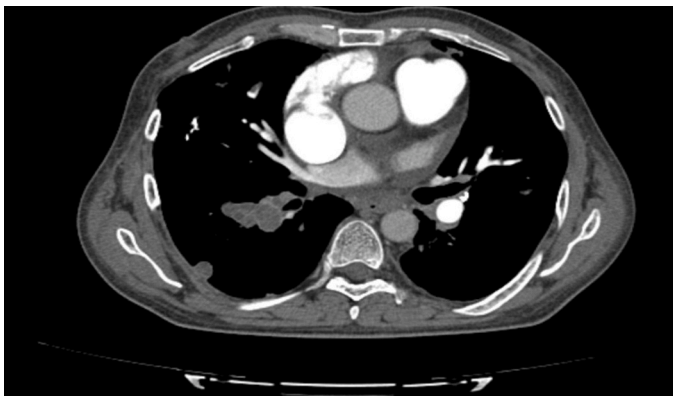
Computed Tomography Pulmonary Angiography(CTPA). The trunk of the pulmonary artery widened and pulmonary artery branches as subsegmental or segmental filled defects.
